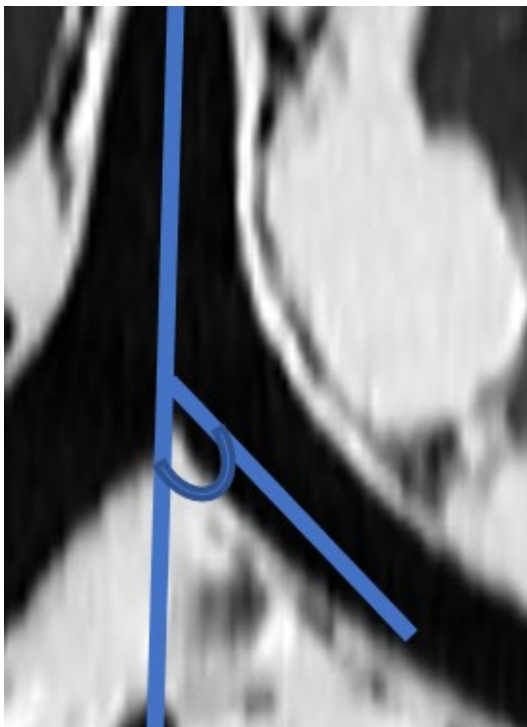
Left main bronchus angle (LMBA): The angle between a vertical line passing through the center of the trachea and a line passing through the center of the left main bronchus on a coronal reformatted CT image
